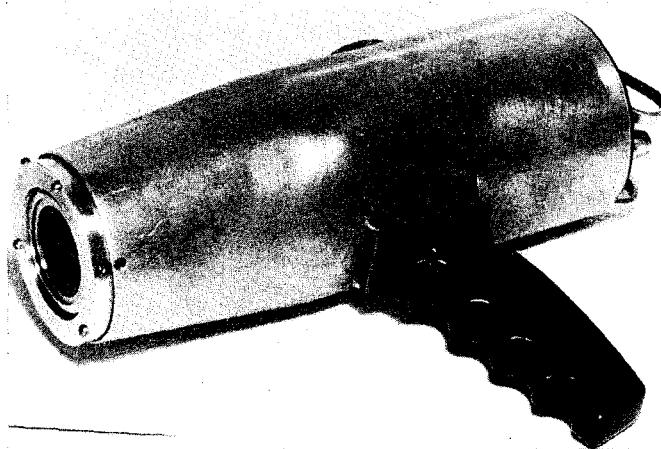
Prototype of selective gamma monitor Type NIS 322 modified for X-ray monitoring.
